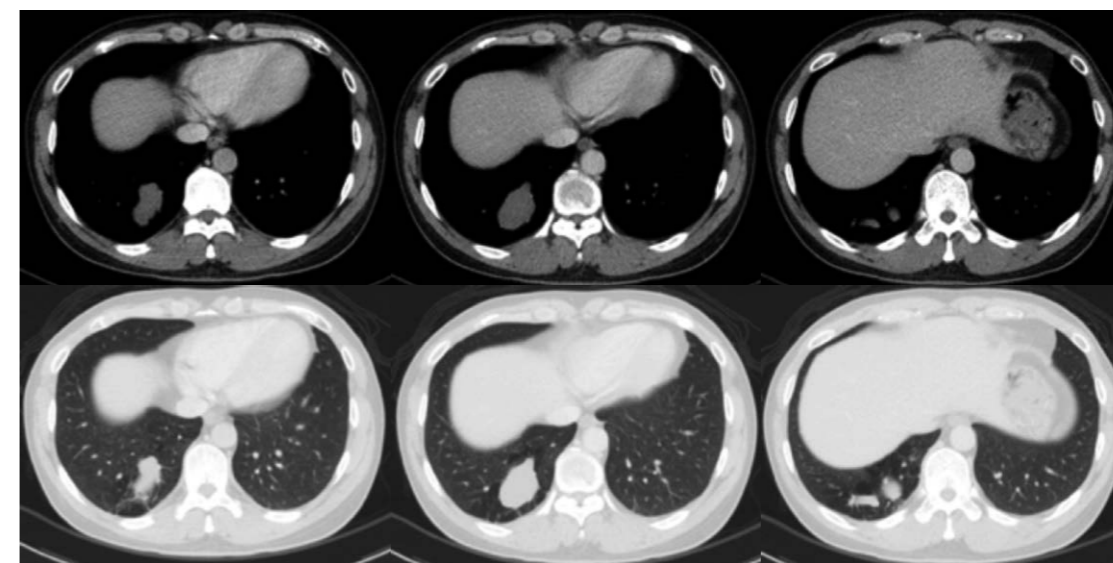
Selected CT sections through the bases of the lower lobes, from superior to inferior. Images on the left were viewed in the soft tissue window, with corresponding images at the same levels on the right viewed in the lung window.
